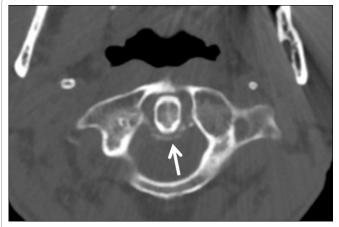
The axial cervical computed tomography image showed semicircular calcification at the posterior side of the dens (arrow).
